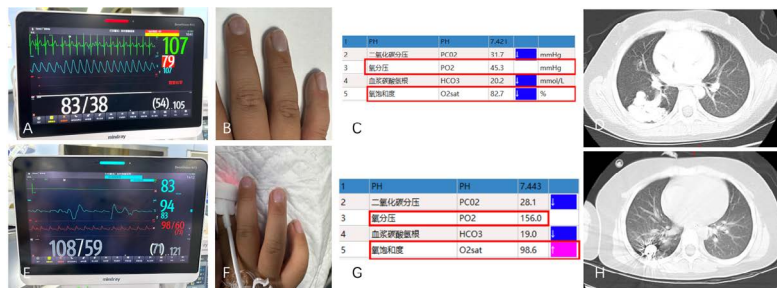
Comparisons between the preoperative and postoperative conditions. Figures A-D display preoperative vital signs, nail bed color, blood gas analysis, and CT results. Figures E-H depict the results of the surgery after it was performed. The oxygen saturation levels were increased, the nail bed turned crimson, and the pulmonary arteriovenous fistula resolved.
